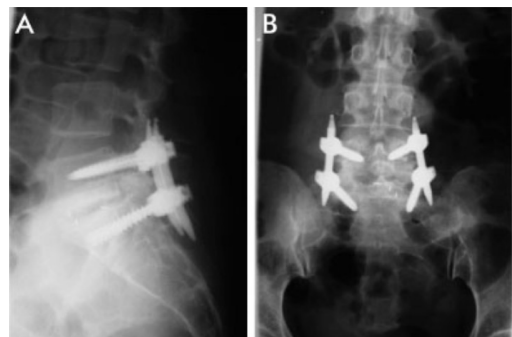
Radiograph of a patient undergoing minimally invasive arthrodesis
